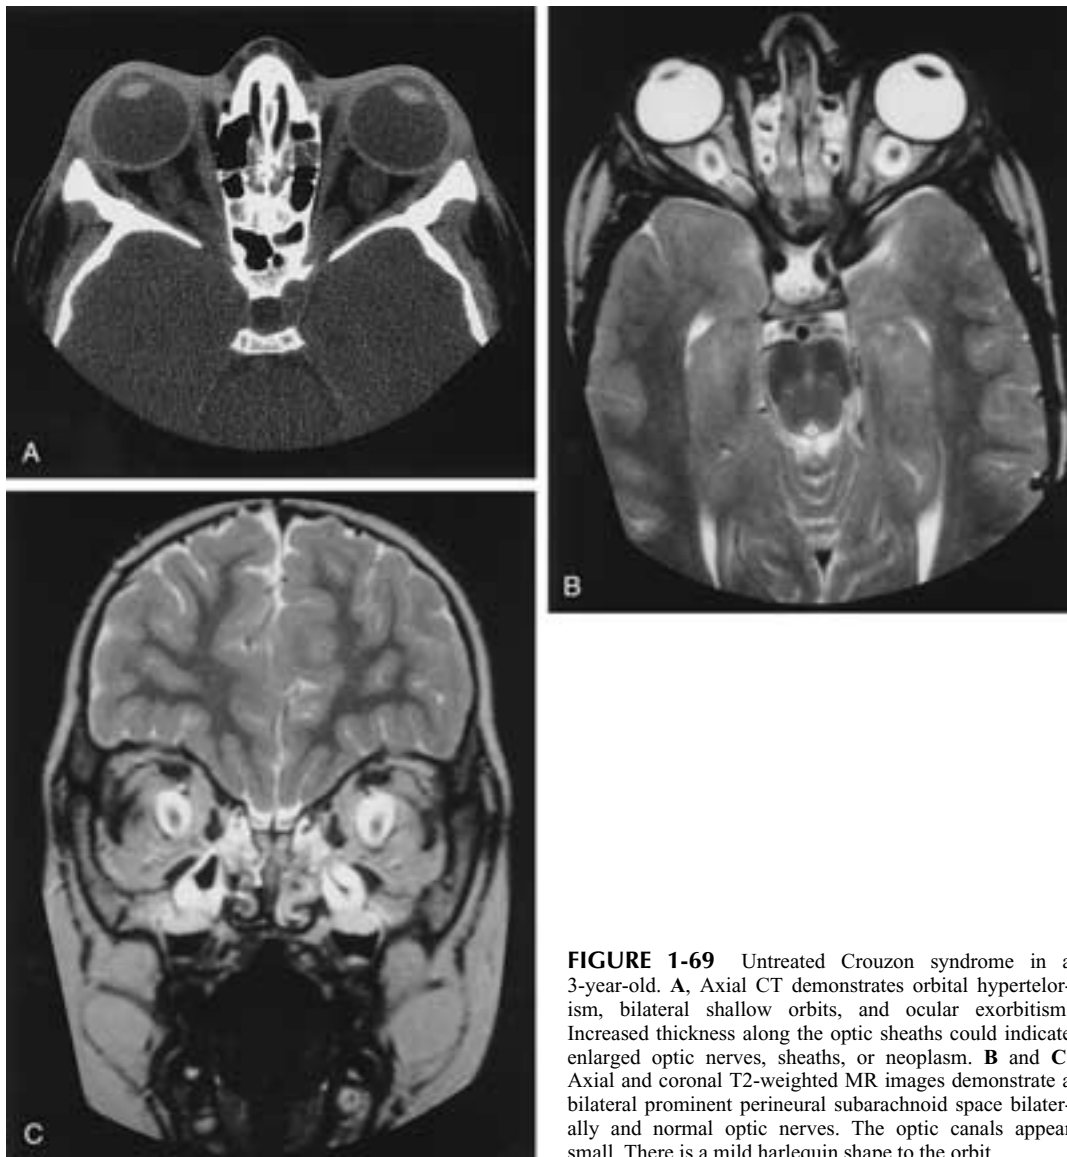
Untreated Crouzon syndrome in a 3-year-old. A, Axial CT demonstrates orbital hypertelorism, bilateral shallow orbits, and ocular exorbitism. Increased thickness along the optic sheaths could indicate enlarged optic nerves, sheaths, or neoplasm. B and C, Axial and coronal T2-weighted MR images demonstrate a bilateral prominent perineural subarachnoid space bilaterally and normal optic nerves. The optic canals appear small. There is a mild harlequin shape to the orbit.
